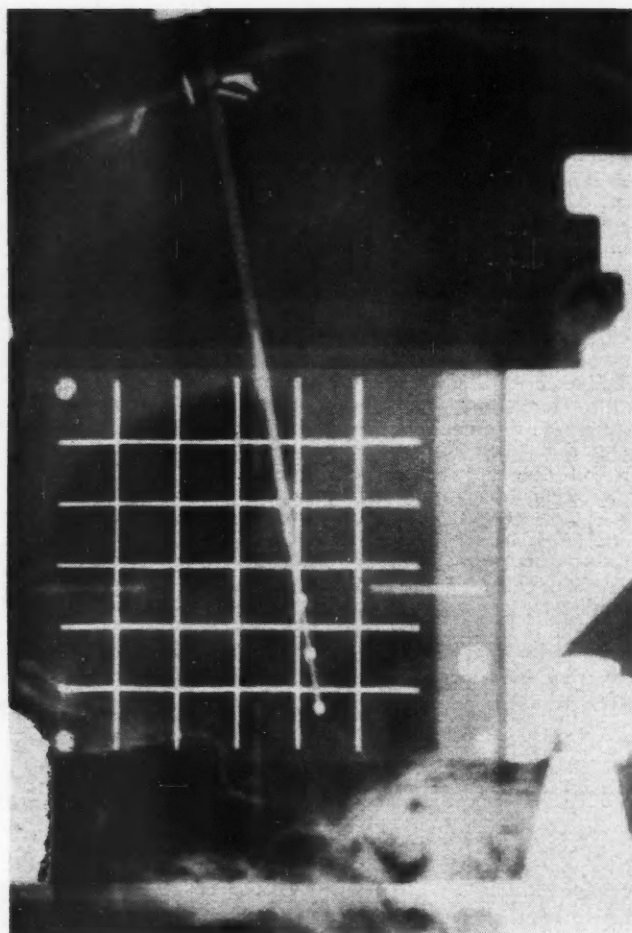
Photograph of x-ray film showing triple-lead needle-electrode in place for stimulation during a procedure. In the desired position, low voltage motor face stimulation is obtained from the lowest contact on the electrode but not from the second one.
